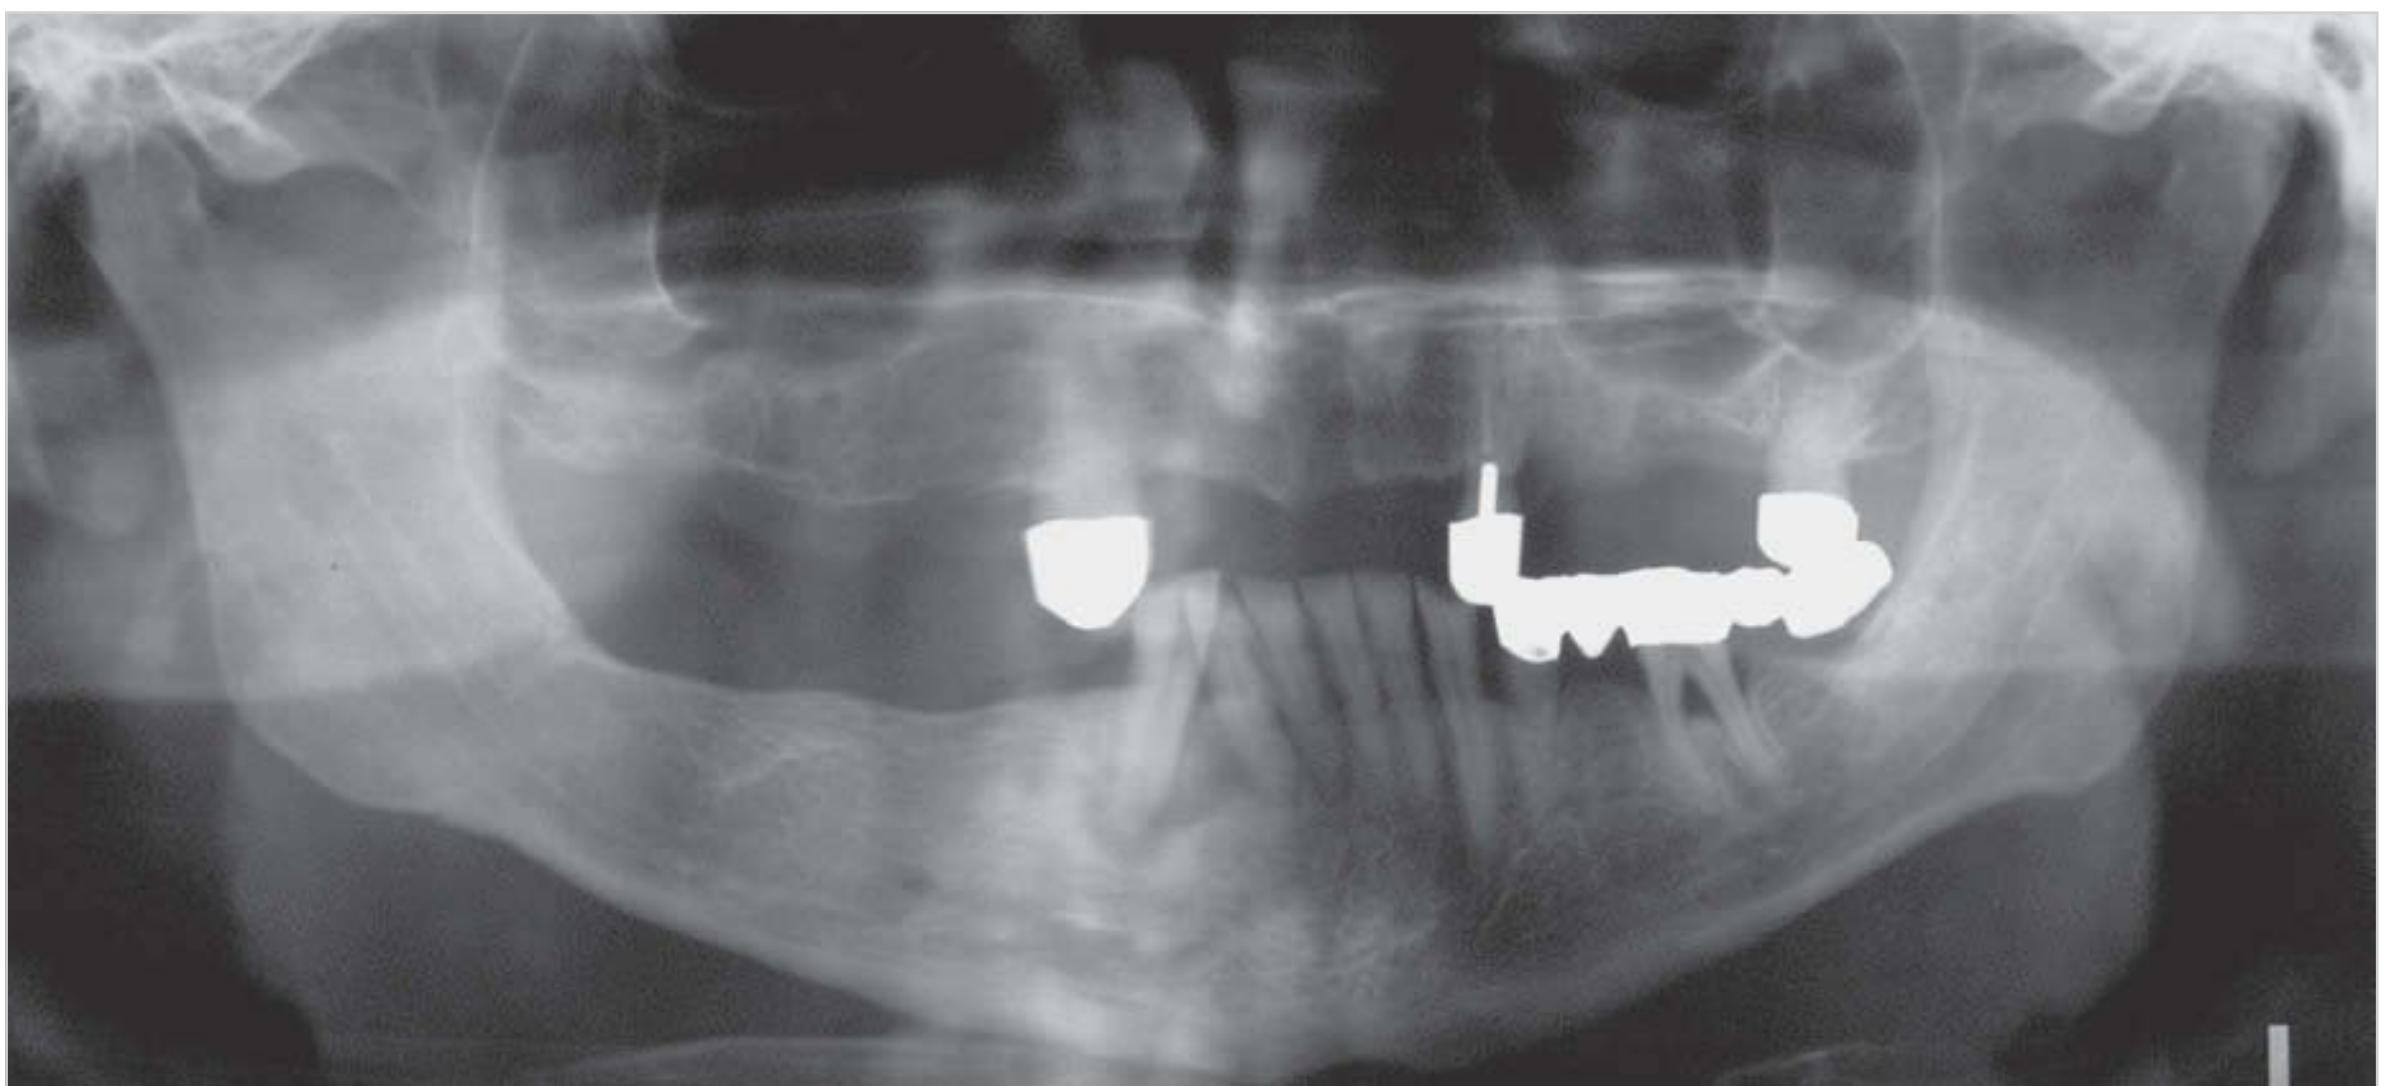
In this panoramic radiograph, taken with the head rotated out of the median plane, the left side appears much wider than the right.
